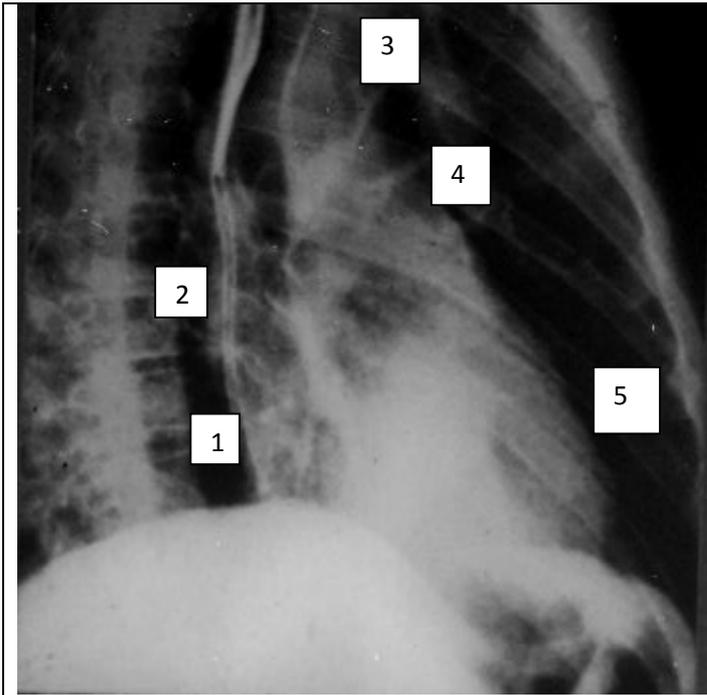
The heart radiograph in the right (first) slanting projection. The contrasted oesophagus settles down rectilinearly. 1-arches of the right atrium, 2-arch of the left atrium, 3-arch of an ascending aorta, 4-arch of the pulmonary cone, 5- left ventriculus arch.
